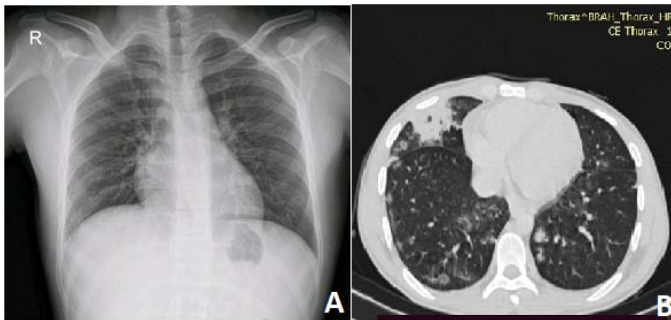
A. Chest X-ray on day 1, B. HRCT Thorax on day 24
